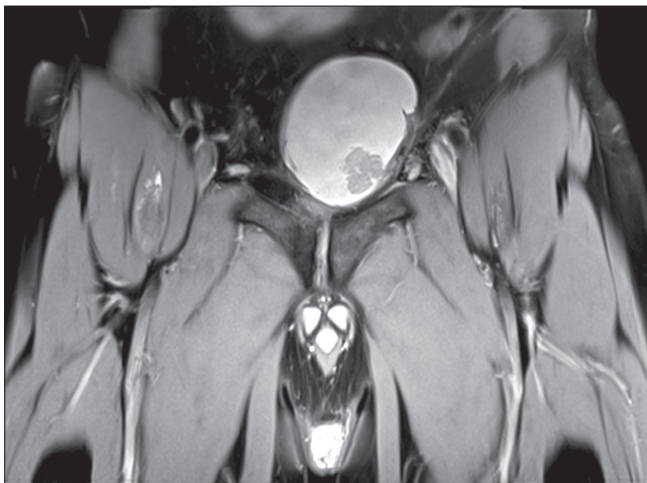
MRI – pathological lesion in the bladder.
